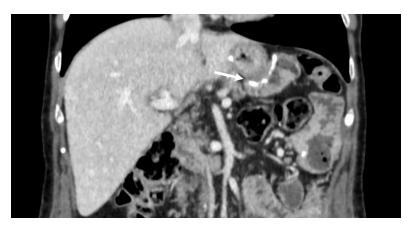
Computed Tomography scan of the patient, showing the gastric remnant and the gastro-enteric anastomosis (white arrow), without signs of recurrence or loco-regional lymphadenopathy.
